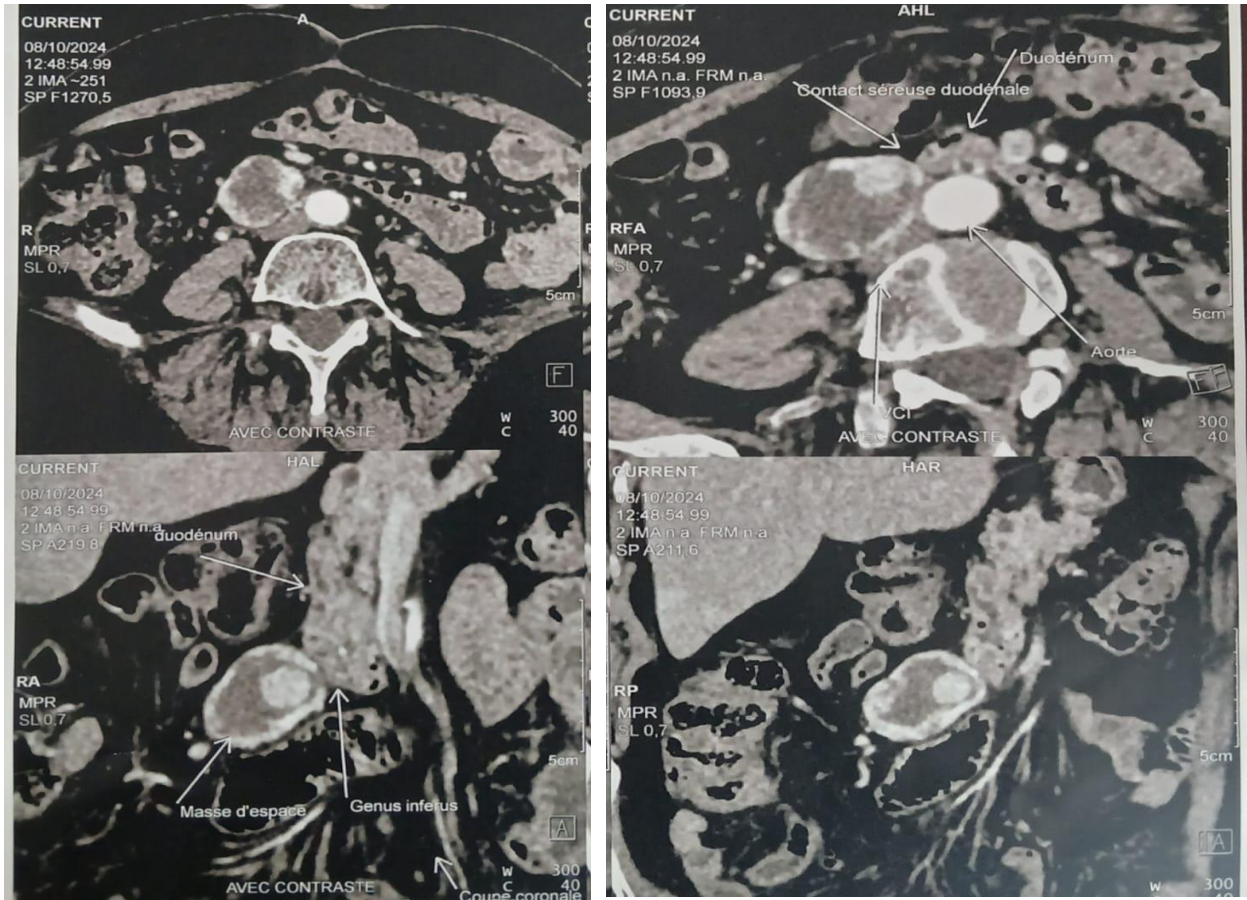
Axial arterial CT scan: a heterogeneous, contrast-enhancing mass in the subduodenal region.
